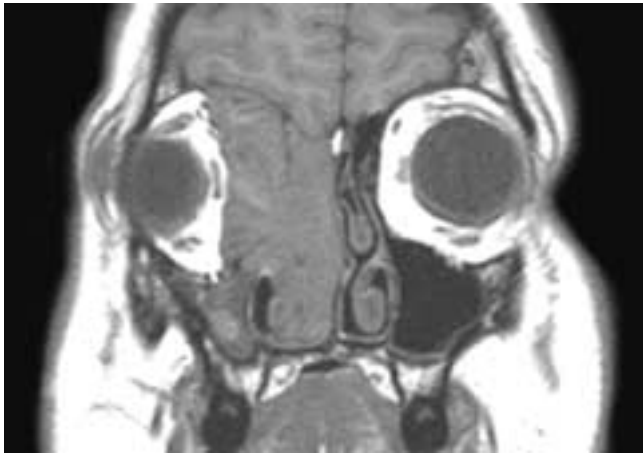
Coronal T1-weighted MR image shows a large intermediate signal intensity mass that fills the right ethmoid complex and nasal fossa. The tumor extends into the right orbit, and there is erosion of part of the roof and medial floor of the right orbit, the fovea ethmoidalis, and the right cribriform plate, as evidenced by the loss of the bone signal void in these areas. The right maxillary sinus is obstructed by the tumor. This patient had a squamous cell carcinoma.
